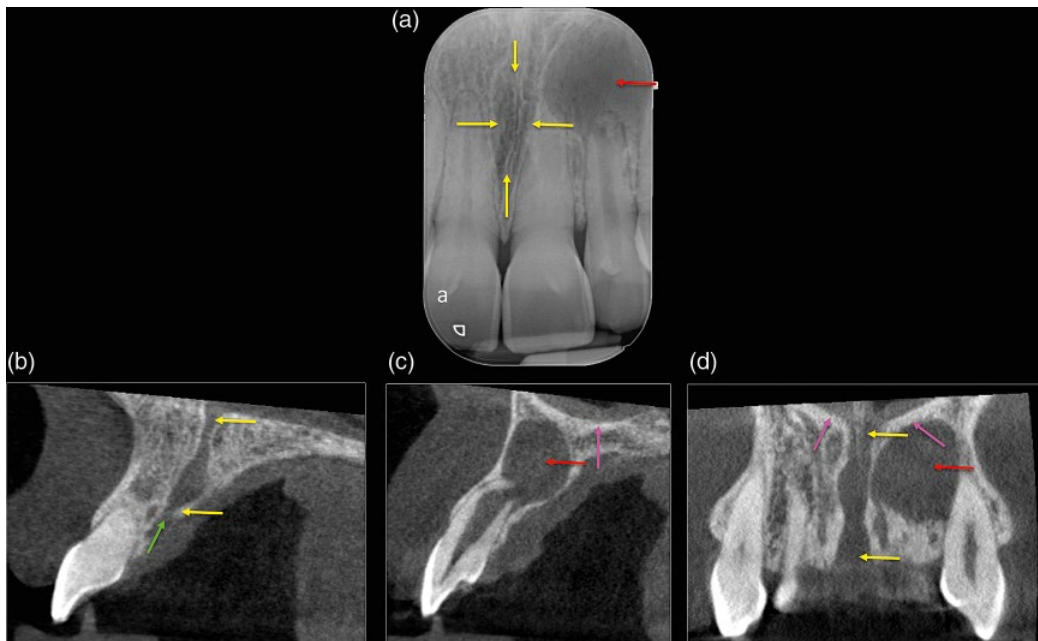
Incisive foramen. (a) Periapical radiograph of teeth 11, 21 and 22. The incisive foramen/canal (yellow arrows) is represented on the radiograph as an elongated radiolucency between teeth 11 and 21. There is a large periapical radiolucency associated with tooth 22 (red arrow). (b) Sagittal CBCT view demonstrating the incisive canal (between yellow arrows) and the incisive foramen (green arrow). (c) Sagittal CBCT view demonstrating the periapical radiolucency associated with tooth 22 (red arrow) and its relationship with the nasal cavity (pink arrow). (d) Coronal CBCT view demonstrating the relationship of the incisive canal (between yellow arrows) to the nasal cavity (pink arrows) and the periapical radiolucency associated with tooth 22 (red arrow).
